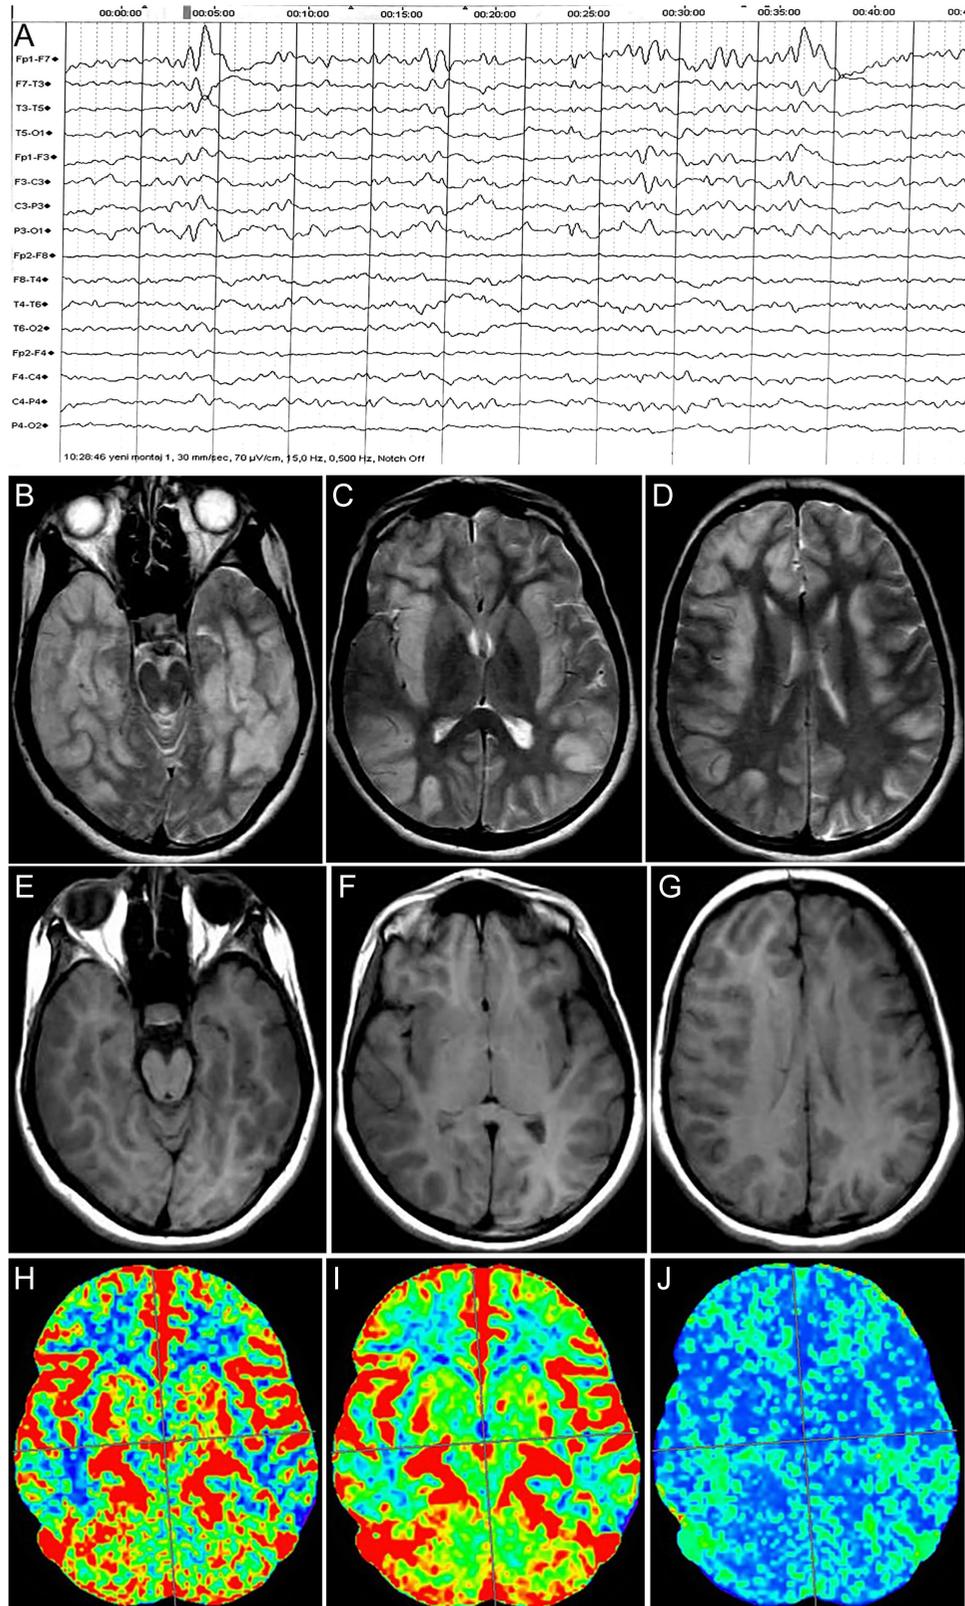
Case 4. (A) The electroencephalogram showing frequent sharp waves in the left hemisphere, with higher amplitude on the frontotemporal electrodes. (B-G) Brain MRI. (B-D) Axial T2-weighted image showing hyperintense signal changes in the bilateral frontal, temporal, and the parietal lobes and the insular cortices. (E-G) Axial T1-weighted image showing hypointense signal changes in the bilateral frontal, temporal, and the parietal lobes and the insular cortices. (H-J) A CTPI of the brain showing increased cerebral blood flow (CBF) and cerebral blood volume (CBV) and decreased mean transit time (MTT), indicating cerebral hyperperfusion. The cross-sectional images of the CTPI were chosen to correspond to the most prominent signal changes on the brain MRI. CTPI, computerized tomographic perfusion imaging; MRI, magnetic resonance imaging.
